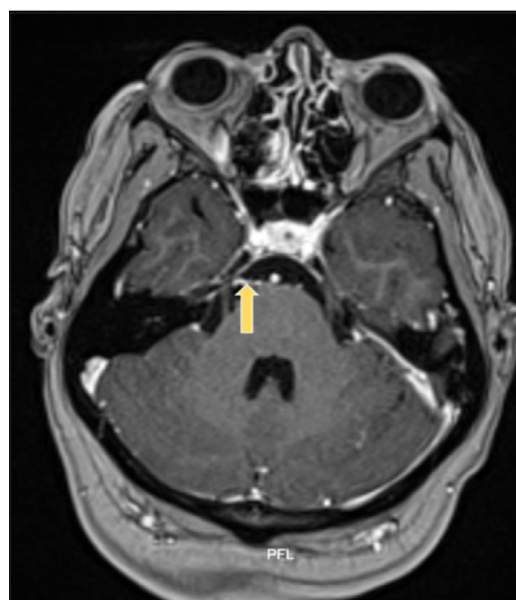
Brain MRI with contrast: T1+Gadolinium sequence: Enhancement along the path of the right cranial nerve VII (indicated by yellow arrow), no other associated findings.
